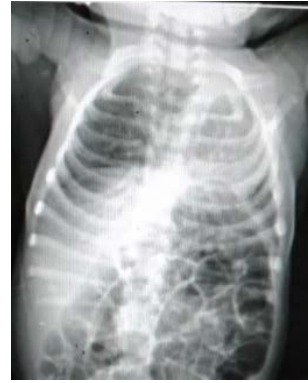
Chest X-ray showed bilateral infiltration predominant in the right lung.
